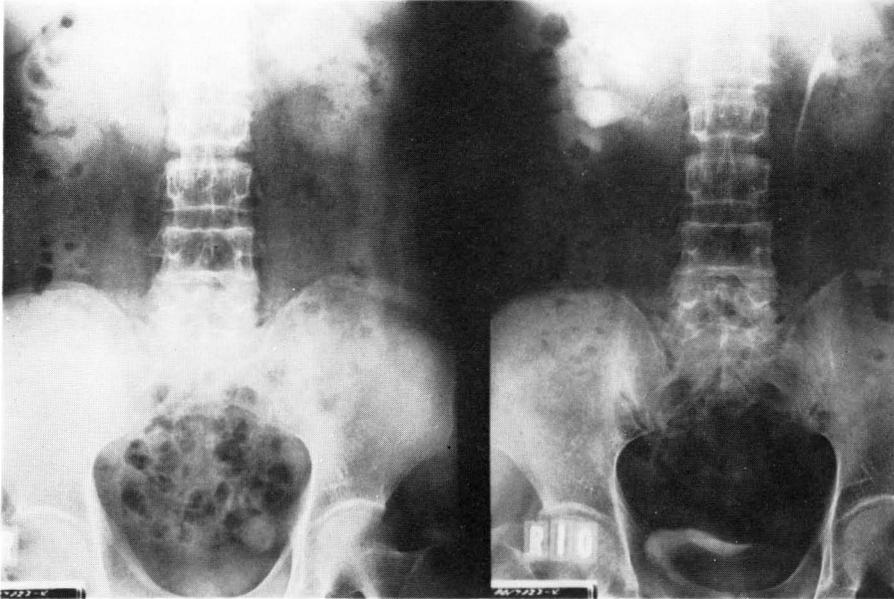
Excretory urogram demonstrating a stone in the right pelvis and ipsilateral hydronephrosis. Right: Plain film. Left: 10 minutes urogram.
